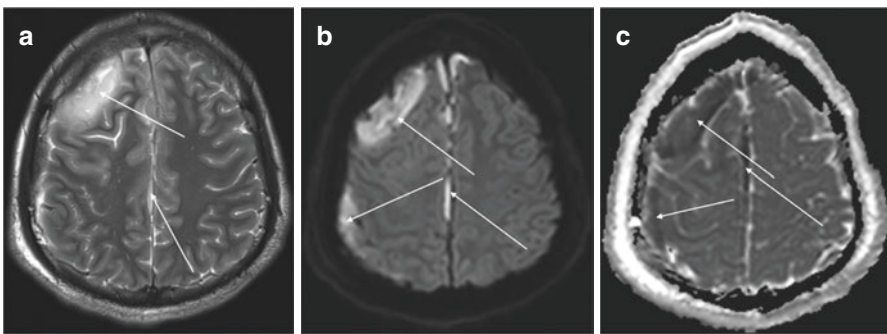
Non-contrast MRI in a patient with a subdural empyema. T2., Apparent Diffusion Coefficient (ADC) and Diffusion weight imaging (DWI) images in axial view showing evidence of signal abnormality in the right frontal subdural space in keeping with a subdural empyema (solid arrows). There is also evidence of disease in the interhemispheric space
